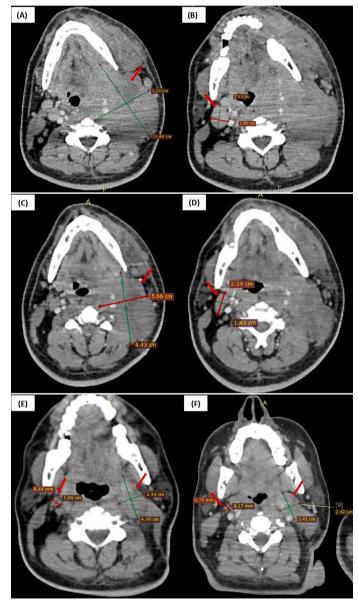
Evaluation of treatment response on CT scans: (A) Initial left cervical lymph node mass. (B) Initial right cervical lymph node mass. (C) Post-COP CT scan showing a reduction in left cervical lymph node mass size. (E) Post-CYVE no. 1 CT scan showing 86 % response rate. (F) CT scan post first cycle of maintenance treatment showing 89 % response rate, indicating complete response.
